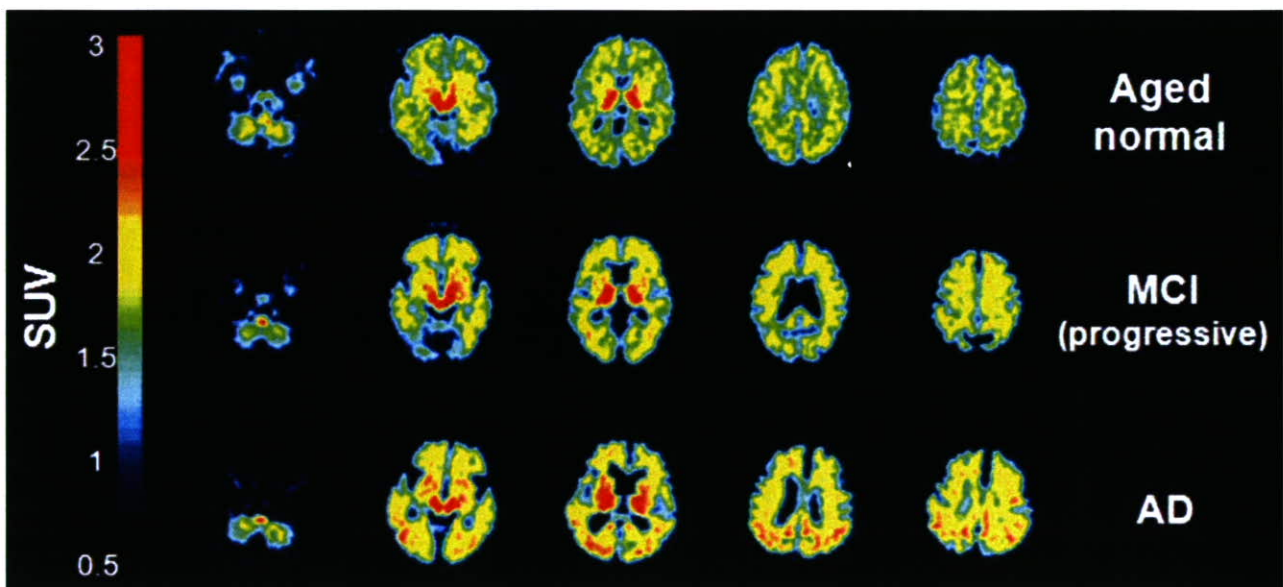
Mean SUV images between 20 and 40 min post-injection of [^{11}C]BF-227 in aged normal, MCI and AD cases.
